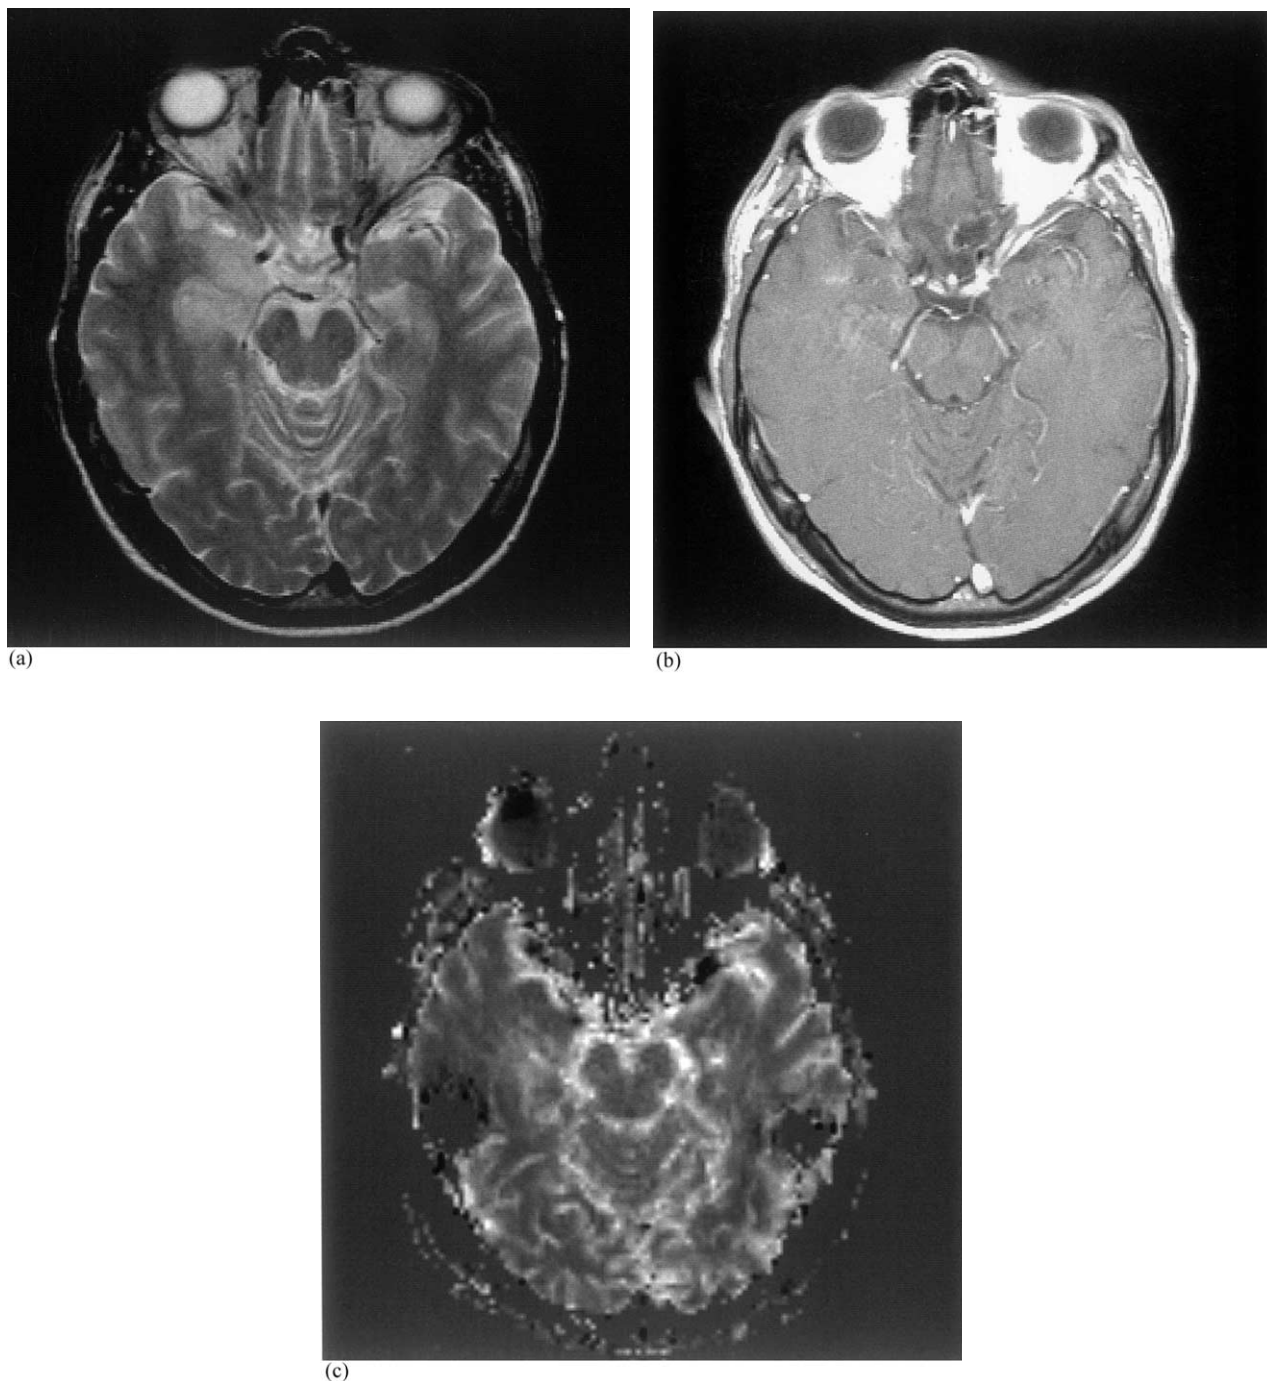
Precontrast T2-weighted image (a), T1-weighted postcontrast image (b) and rCBV map (c) from a 39-year-old man suffering from an astrocytoma grade II with hyperintense signal alterations in T1 and EPI indicating contrast media enhancement. A dark grey shade corresponds to low and a light grey shade to high perfusion. The appearance of the tumor on these images is characteristic of astrocytomas grade II investigated in this study. Typically, they do not show edema in the precontrast T2-weighted images nor a distinct contrast agent enhancement in the T1-weighted images. There was no clear enhancement of rCBV in the tumor region in particular.
